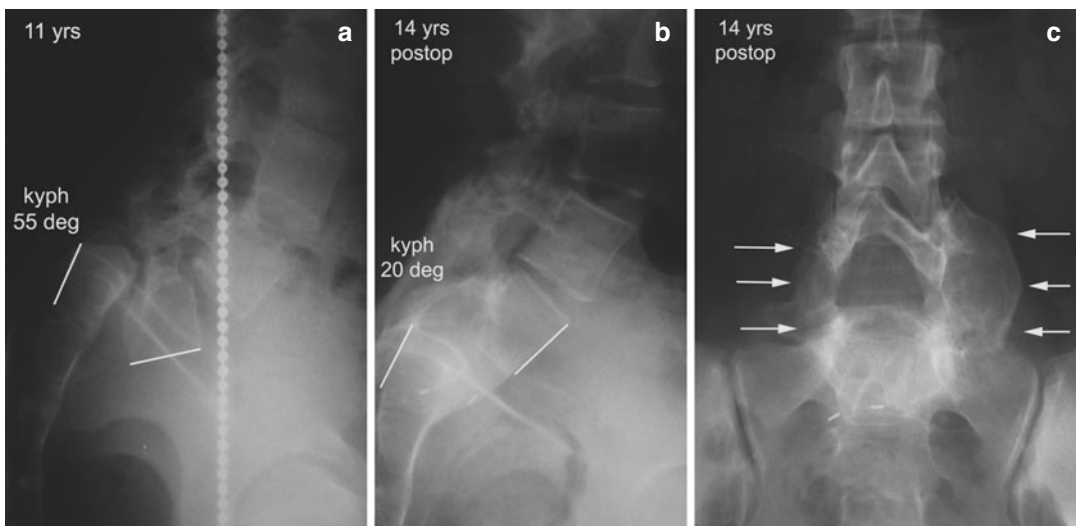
Bilateral L5 laminectomy, instrumented reduction and anterior/posterolateral fusion L4-S1 for spondyloptosis. (a) Standing lateral radiograph of an 11-year-old girl with L5 spondyloptosis. (b) Lateral
